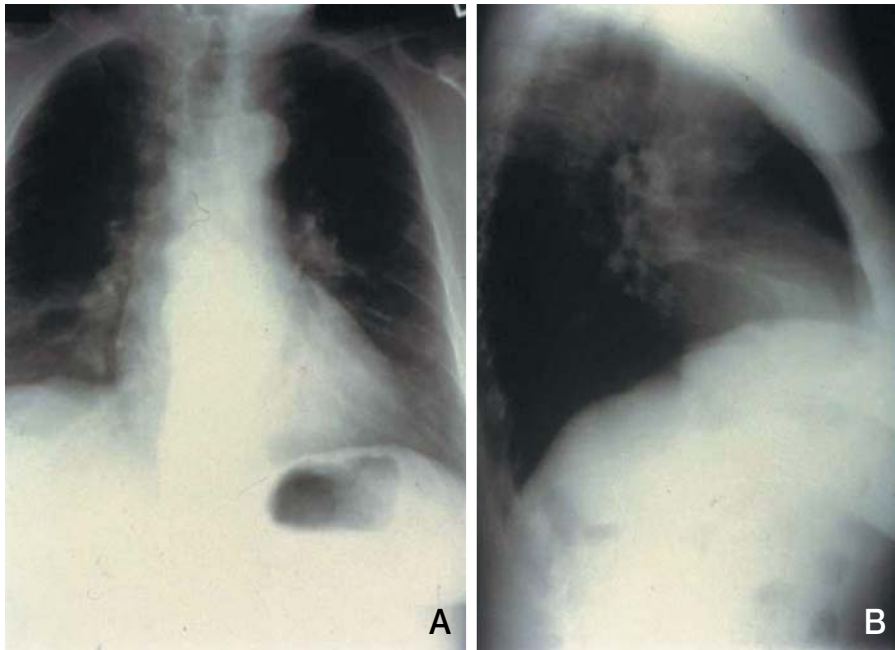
Results of postero-anterior (A) and lateral (B) chest radiographs reveal multiple pulmonary nodules, bilateral hilar enlargement, and no pleural effusion.
